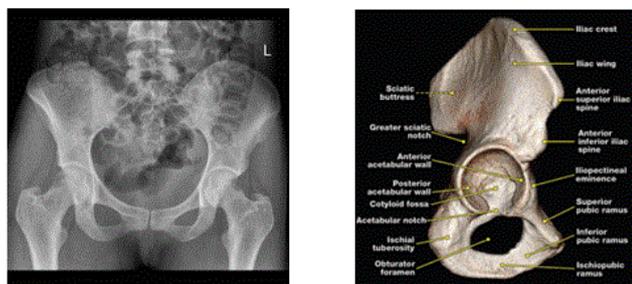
Normal annotated x-ray [30], Lateral surface-rendered 3D CT image shows the acetabulum [31]
